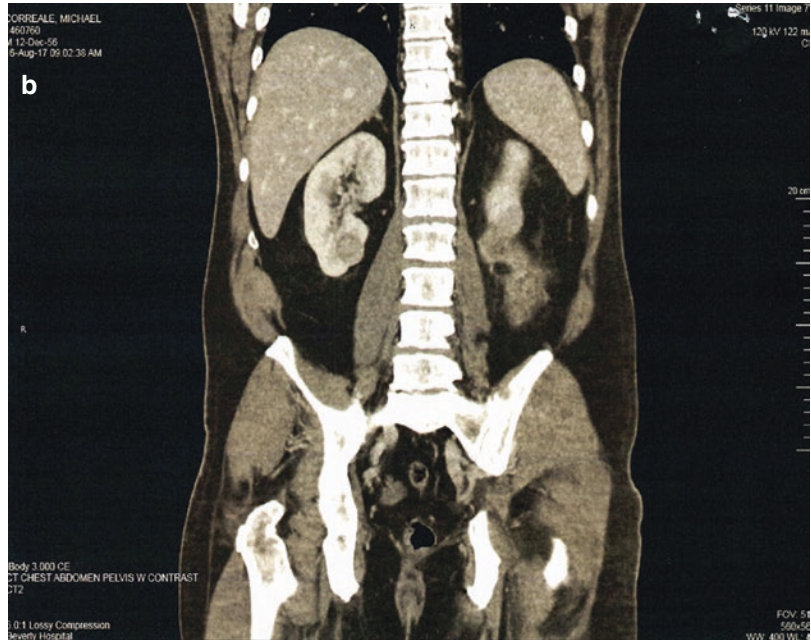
Case Study 2. (a) Preoperative CT scan demonstrating large right renal tumor and midpolar left renal tumor. (b) Preoperative CTA scan of large right renal tumor and midpolar left renal tumor, without evidence of adenopathy or venous involvement. (c-d) The intraoperative photographs of the midpolar partial nephrectomy site, reconstruction of the kidney and the excised renal tumor
